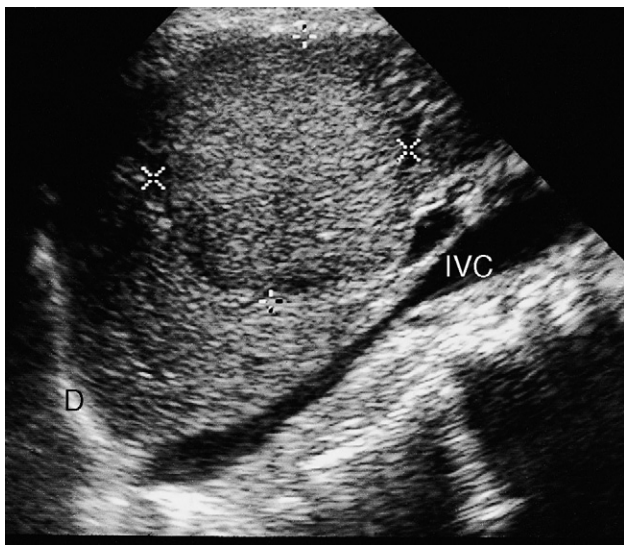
Ultrasound of a solid mass. Longitudinal scan showing an echogenic mass (indicated by cursors), which proved to be a metastasis. D, diaphragm; IVC, inferior vena cava.
